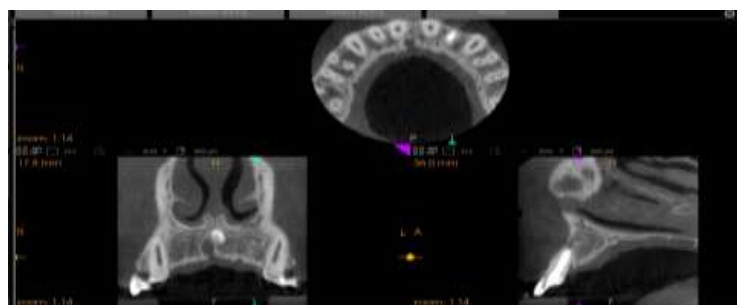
CBCT after 6 months
